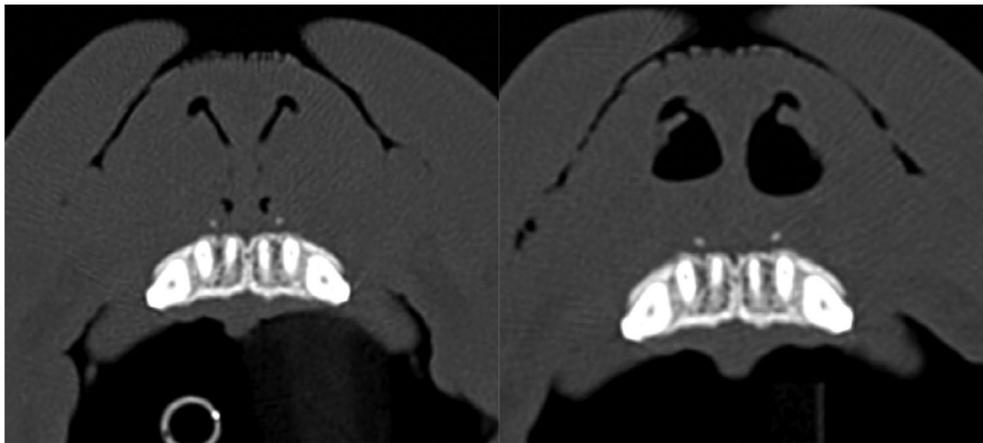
Transverse sections of a French Bulldog head CT of the nasal vestibule at point 2 preoperatively (left) and postoperatively (right).
